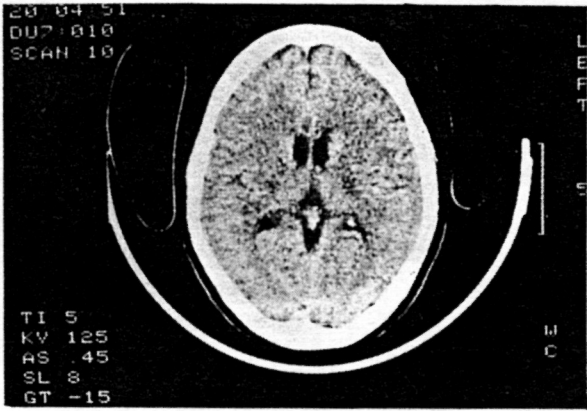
No specific finding in brain CT can be seen.
